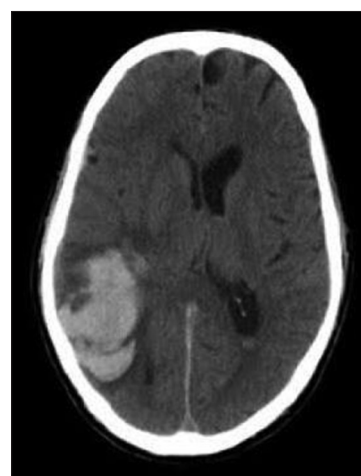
CT Scan of Brain showing parenchyma hematoma with associated edema causing midline shift
